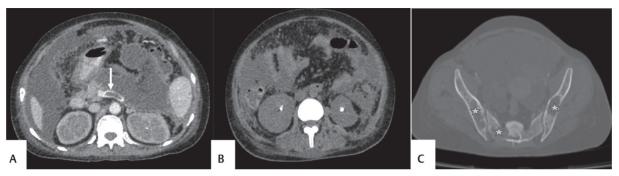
(A) Contrast-enhanced CT abdomen, axial section shows ill-defined peripherally enhancing collection involving body and tail of pancreas, suggesting acute necrotizing pancreatitis with gross ascites and splenic vein thrombosis (arrow). (B) Plain CT abdomen, axial section shows multiple renal calculi seen in bilateral kidneys (C) Plain CT pelvis, axial section, bone window shows multiple osteolytic lesions involving right ala of sacrum and bilateral iliac wings (asterisk).
